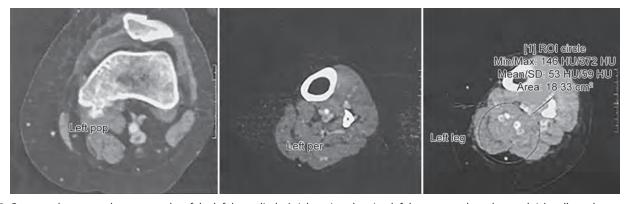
Computed tomography venography of the left lower limb. Axial section showing left leg venous thrombus and rich collaterals
